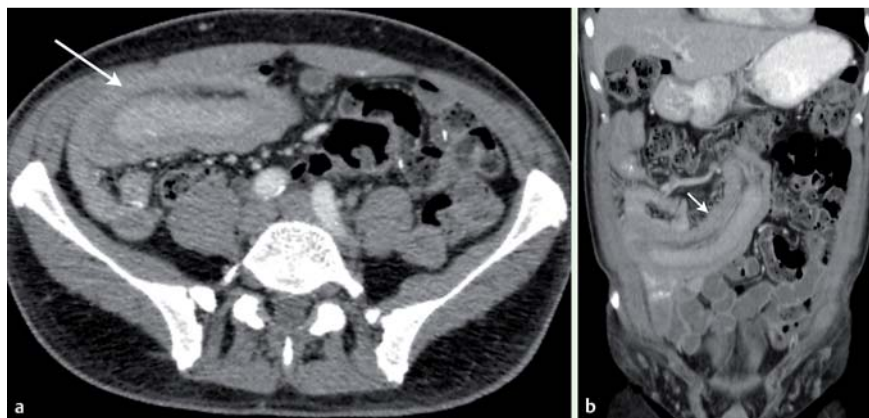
Jejunal intussusception revealed by computed tomography (CT) scan: a axial view; b coronal view.
